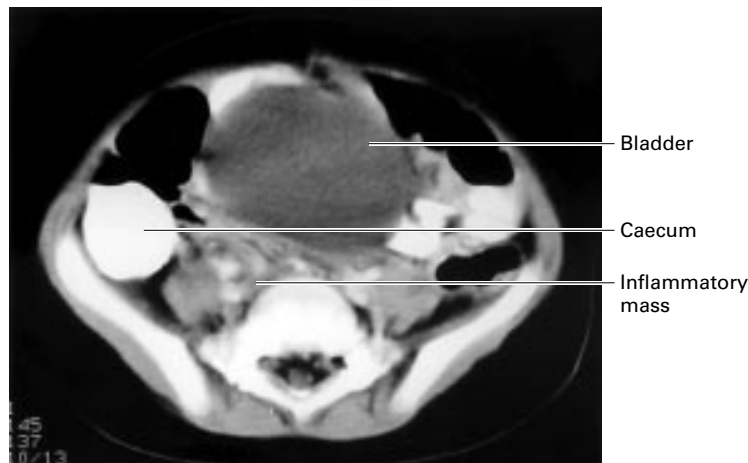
CT scan shows the relation of the inflammatory mass to the bowel. The caecum contains contrast and is dilated.
